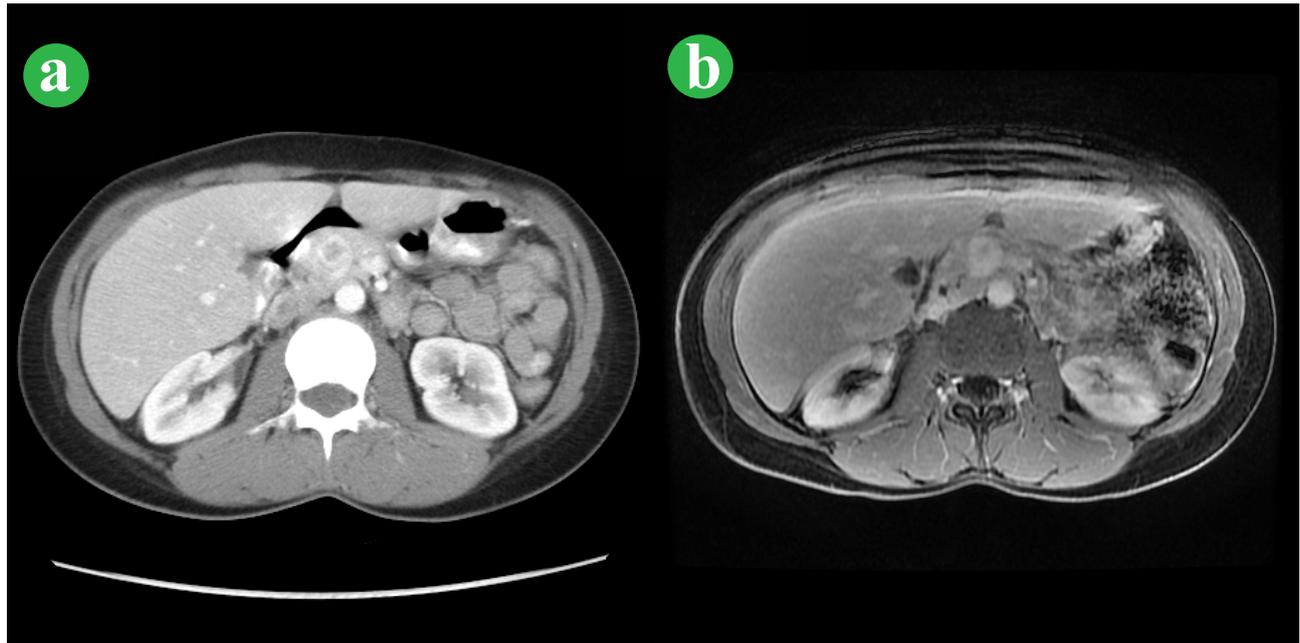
(a). Computed tomography of the abdomen with intravenous contrast showing 1.8 cm × 1.2 cm well-circumscribed mass in the pancreatic head. (b). Magnetic resonance imaging of the abdomen showing pancreatic head mass at 2 cm × 1.7 cm with central hypoenhancement.
